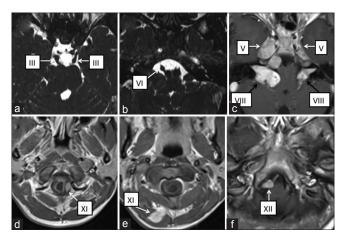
(a) Magnetic resonance imaging constructive interference in steady state images axial sections showing bilateral 3rd nerve schwannoma, (b) magnetic resonance imaging constructive interference in steady state images axial sections showing right 6th nerve schwannoma, (c) postcontrast magnetic resonance imaging images axial sections showing bilateral 5th and 8th nerve schwannoma, (d and e) postcontrast magnetic resonance imaging images axial sections showing intraspinal and extraspinal components of 11th nerve schwannoma, (f) postcontrast magnetic resonance imaging images axial sections showing 12th nerve schwannoma
